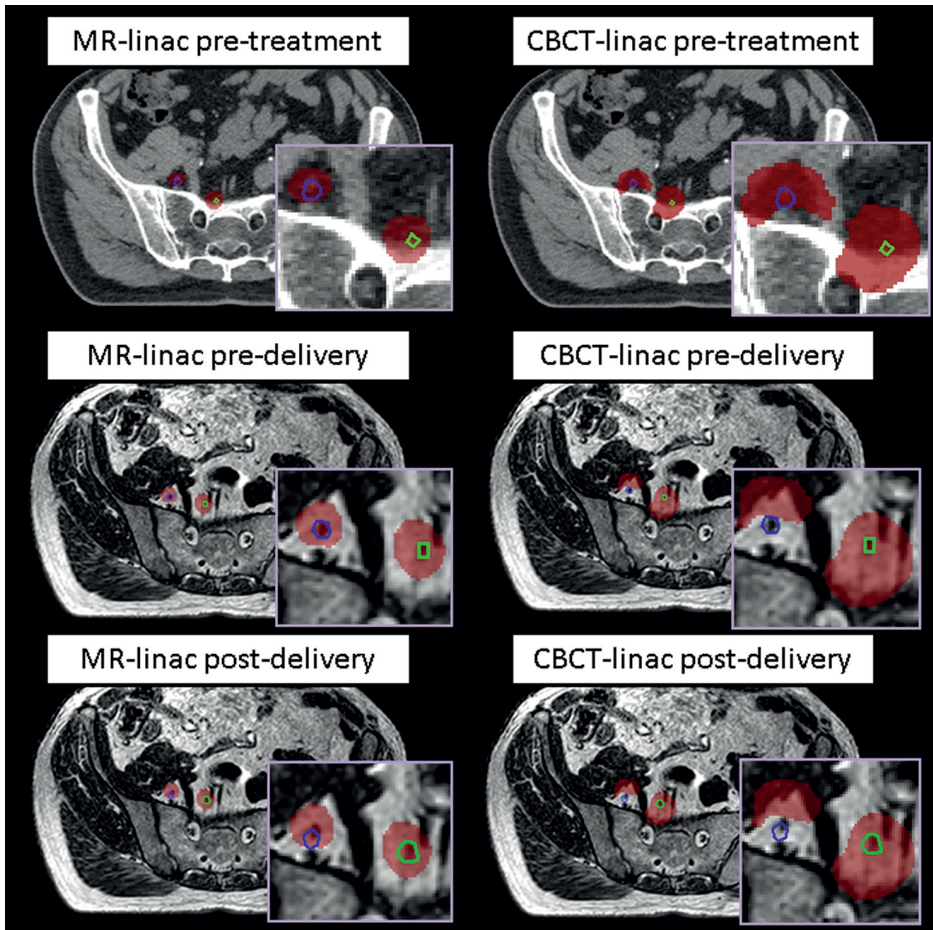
Pre-treatment, pre-delivery and post-delivery example of a multiple lymph node oligometastases case with three targets. Visible are the two most distal GTVs (blue and green) the 35 Gy dose level (red). Geometrical variations, causing independent motion of the targets, would have led to under-dosage ($V_{35\text{Gy}}$ of 8.9%) of the distal GTV (blue) when using the CBCT-linac plan in the pre-delivery situation and under-dosage ($V_{35\text{Gy}}$ of 0%) in the post-delivery situation, regardless of the use of a 8 mm PTV margin. GTV coverage remained adequate with a $V_{35\text{Gy}}$ of 100% for the MR-linac plans, using 3 mm PTV margins.
